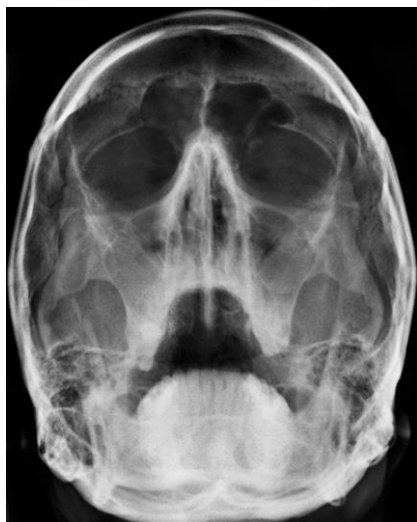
A Waters radiograph showing maxillary sinus mucosal thickening.
